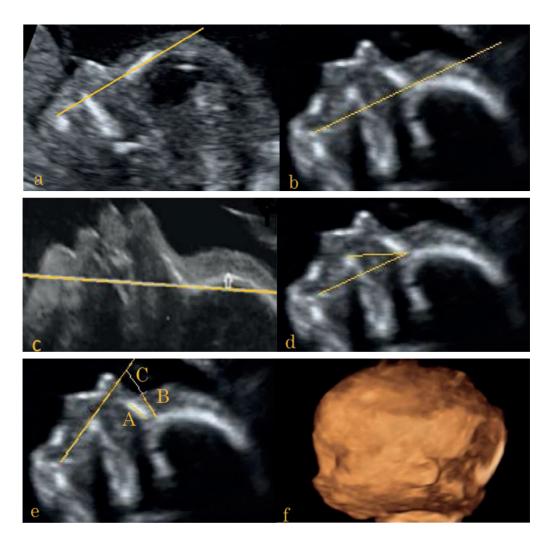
Ultrasound images of the markers in T18 fetuses, except for the fetus in image c, which is euploid. (a) FP line position 'zero'; (b) FP line position 'negative'; (c), FP line position 'positive'; (d) MNM angle; (e) NBL (A), PT (B), PT-NBL ratio (B/A), PFSR (C/B); (f) 3D reconstruction of T18 fetus. FP, fetal profile; MNM, maxillanasion-mandible; NBL, nasal bone length; PT, prenasal thickness; PFSR, prefrontal space ratio. The FP line was defined as the line that passes through the middle point of the anterior border of the mandible and the nasion. The nasion was defined as the most anterior point in the junction between the frontal and nasal bones. When the FP line passed lengthwise through the frontal bone, this was called 'zero' (Figure 1,a). When the FP line passed the frontal bone anteriorly its position was called 'negative' (Figure 1, b). When the FP line passed the frontal bone posteriorly, its position was called 'positive' (Figure 1, c). The MNM angle was defined as the angle in the median plane between the lines maxilla-nasion and mandible-nasion (Figure 1, d). NBL was measured from the nasion to the end of the white distal ossification line (Figure 1, e A). In cases in which there was a gap between the nasal and the frontal bones (disjunction), the NBL was measured from the distal to the proximal end of the ossification line. To measure the PFSR, first the maxilla-mandible line was drawn between the midpoint of the anterior edge of the mandible and the anterior edge of the maxilla. The line was then extended cranially towards the forehead. Subsequently, the skin covering the forehead was measured between the anterior edge of the bony forehead and the anterior edge of the skin in a line that is parallel to the maxilla and that is traced from the nasion. This measurement is called the prenasal thickness (PT, Figure 1, e B). A second measurement d (Figure 1, e C), was taken starting from the anterior edge of the skin (where PT ended), to the point of interception with the MM line. The PFSR was determined by dividing d by PT. The PT-NBL ratio was constructed by dividing PT by NBL. All markers were measured in the same plane.
